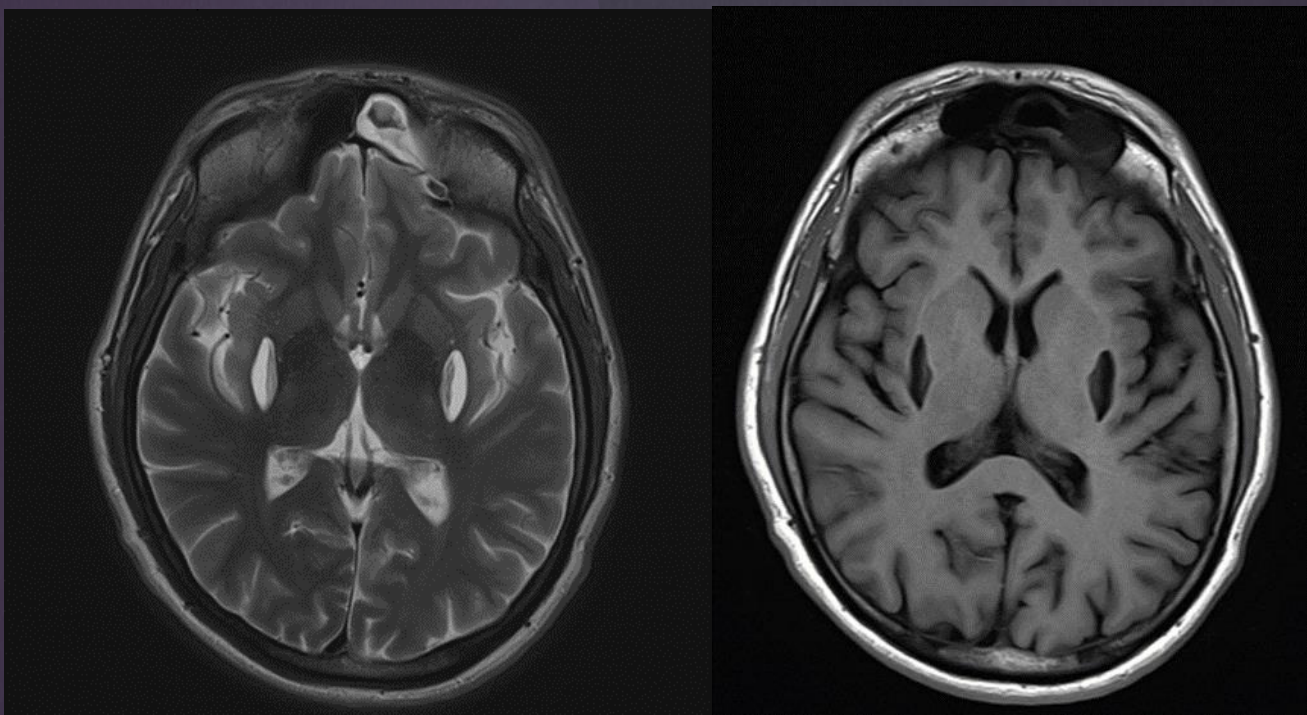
MRI brain of a patient showing bilateral putamen necrosis
